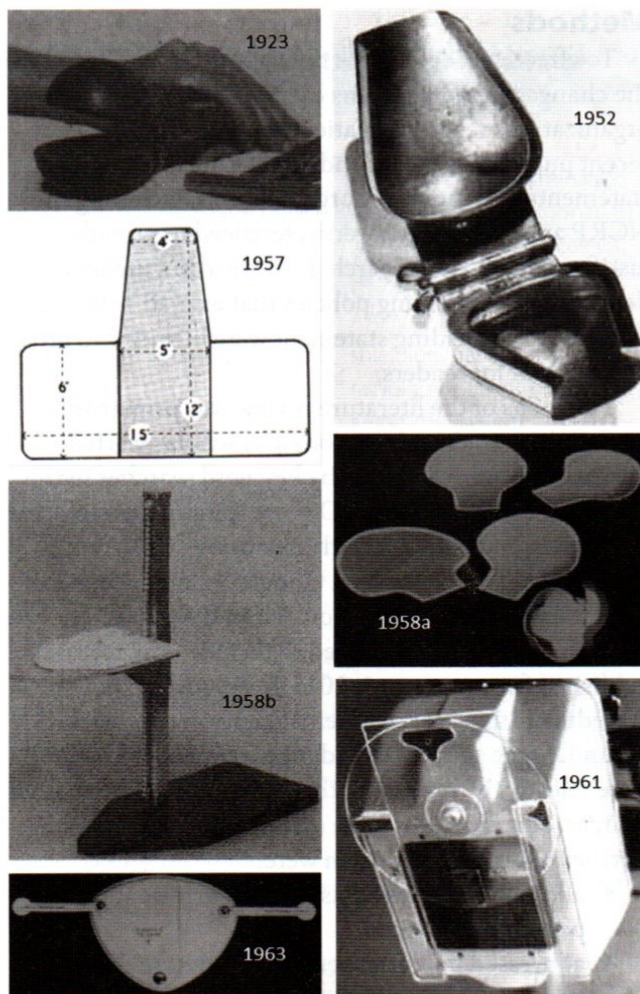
Examples of gonadal shields used in diagnostic imaging with the year they were described in the literature. Reprinted under the Creative Commons Attribution 4.0 International license. Jeukens CRLPN, Kütterer G, Kicken PJ, et al. Gonad shielding in pelvic radiography: modern optimised x-ray systems might allow its discontinuation. *Insights Imaging.* 2020;11(15). doi:10.1186/s13244-019-0828-1. creativecommons.org/licenses/by/4.0/
